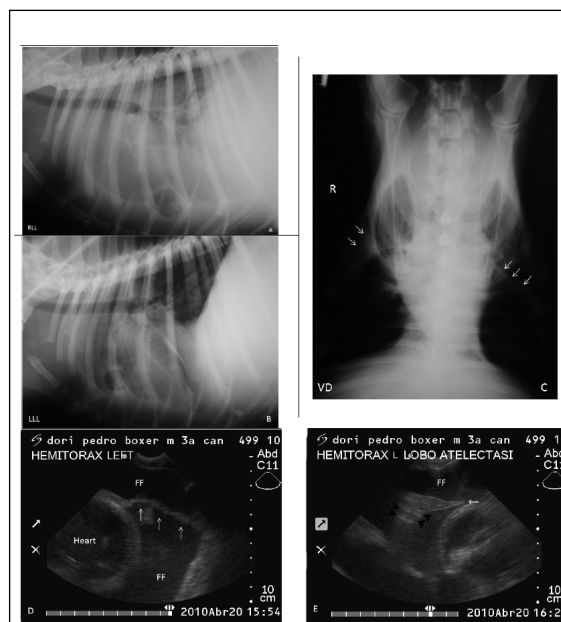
Radiographic and ultrasound examinations of a male 3-year-old Boxer. Radiographic examination on the right and left laterolateral projections (RLL and LLL) and ventrodorsal projection (VD) (Figures 2A, B and C) revealed an increase in the homogeneous water radiopacity in the pleural space and dispersed throughout the thorax, leading to visualization of the interlobar incisions (white arrows) and retraction of the lung lobes (atelectasis), resulting in delimitation of their borders. It is difficult to identify the diaphragm and heart. The B-mode ultrasound examination (Figures D and E) shows the phreno-pericardial ligament (white arrows), confirming the presence of a large quantity of free fluid (FF) in the pleural space (Figure D) and the presence of an atelectatic lung lobe (arrows) (Figure E).
